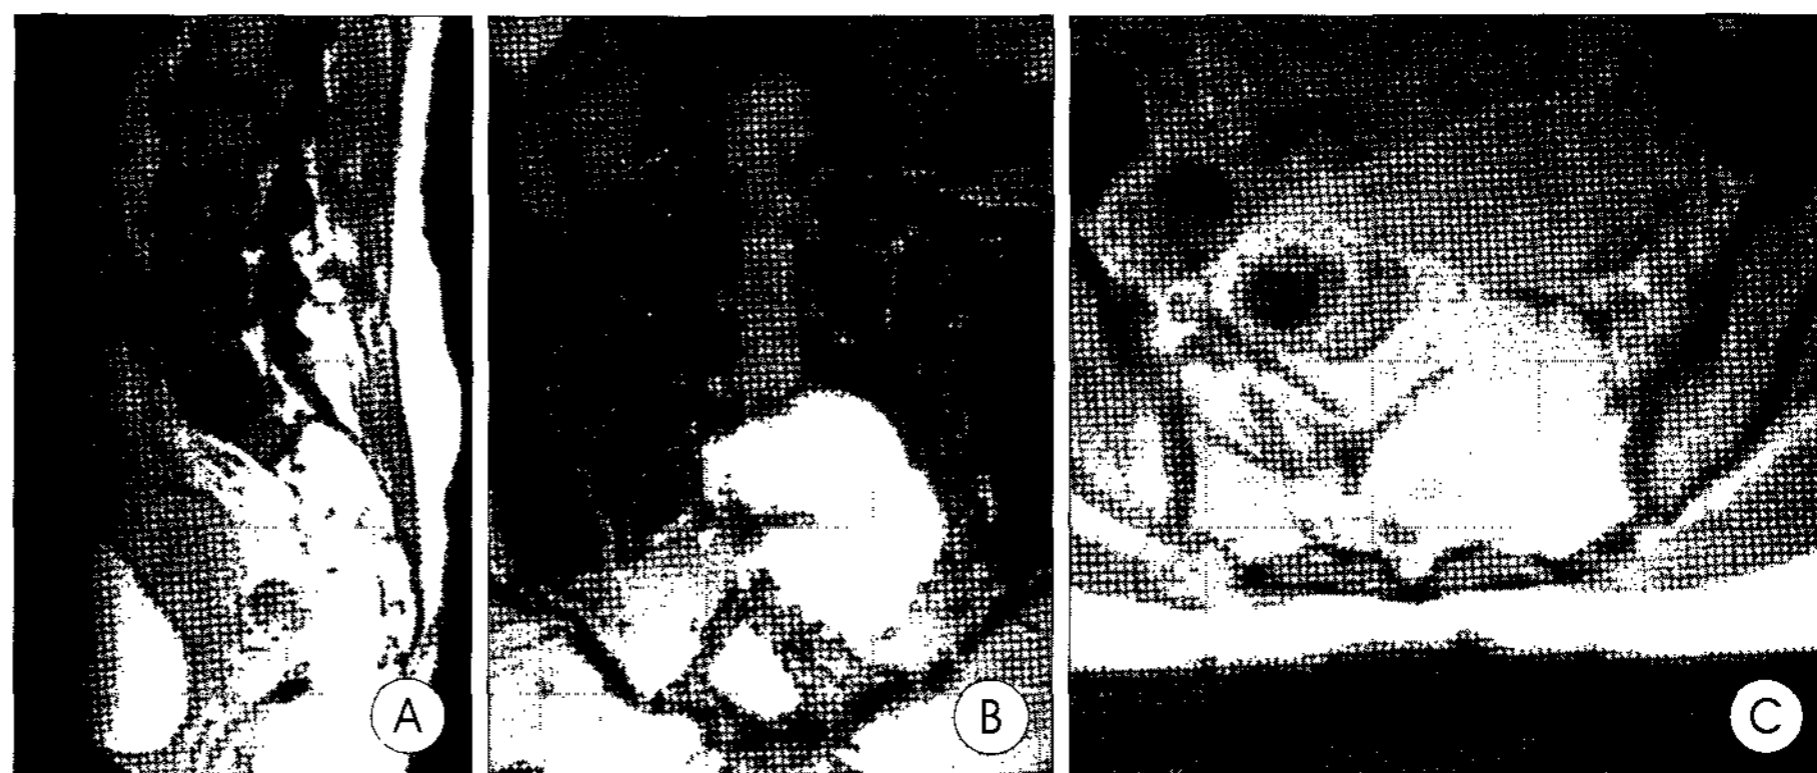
A 49-year-old woman is admitted to our hospital with a history of mild lower back pain for 1 month. A, B, C : The gadolinium enhanced sagittal, coronal, and axial magnetic resonance images reveal strong enhancing tumor mass lesion on the 2nd and 3rd sacrum area.
